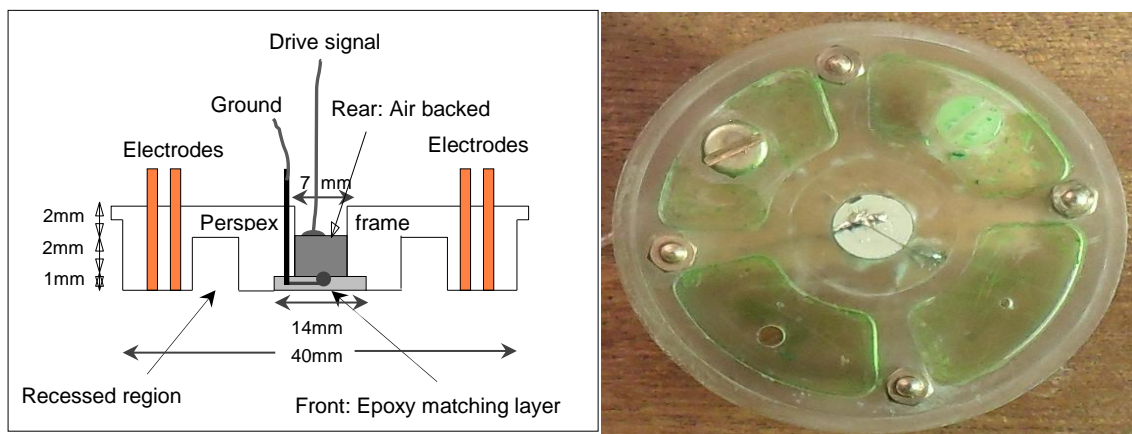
(a) Cross section of the perspex lid of the test cell. Electrode positions are shown as distorted so that all 4 electrodes are visible. (b) The completed Perspex lid – the PZT ultrasound transducer and the electrodes are fitted in the perspex lid.
